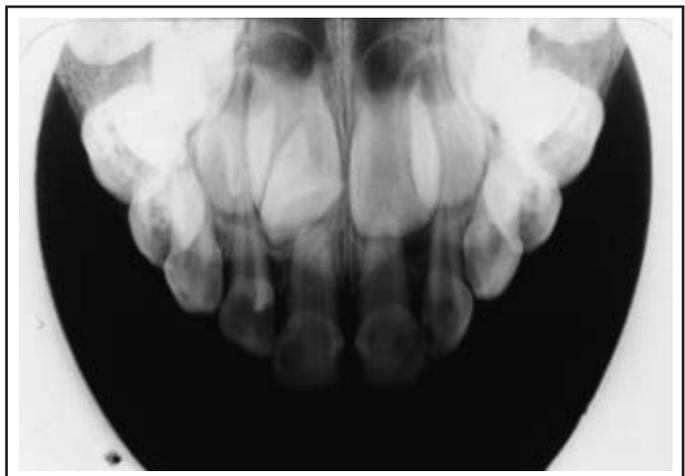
Case 2. An upper anterior occlusal radiograph showing talon cusps on the primary maxillary right lateral incisor and the distal supplemental permanent lateral incisor.
